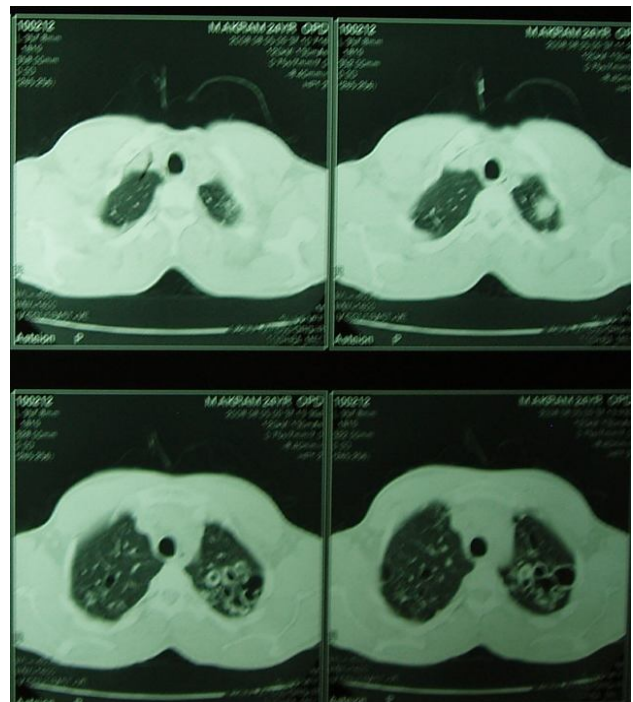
HRCT chest showing bilateral bronchiectatic changes involving upper lobes.
